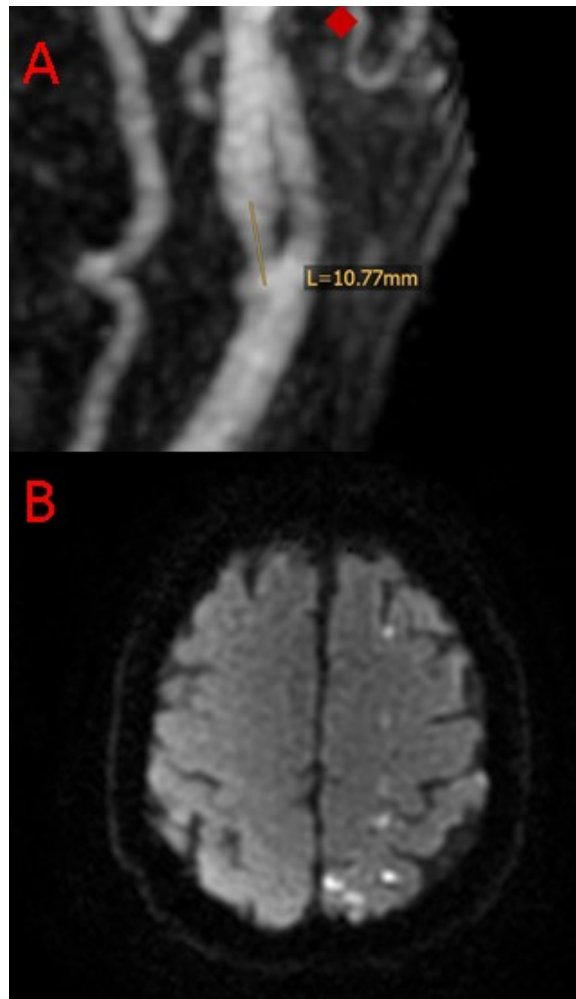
A. MRA (patient 81) showing an ICAD with a length of 11 mm, B. DWI-MRI showing multiple small infarctions
